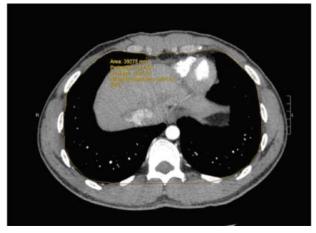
Representative CT scan demonstrating measurement of TAC by measuring the circumference of the body at the level of the dome of the liver.
